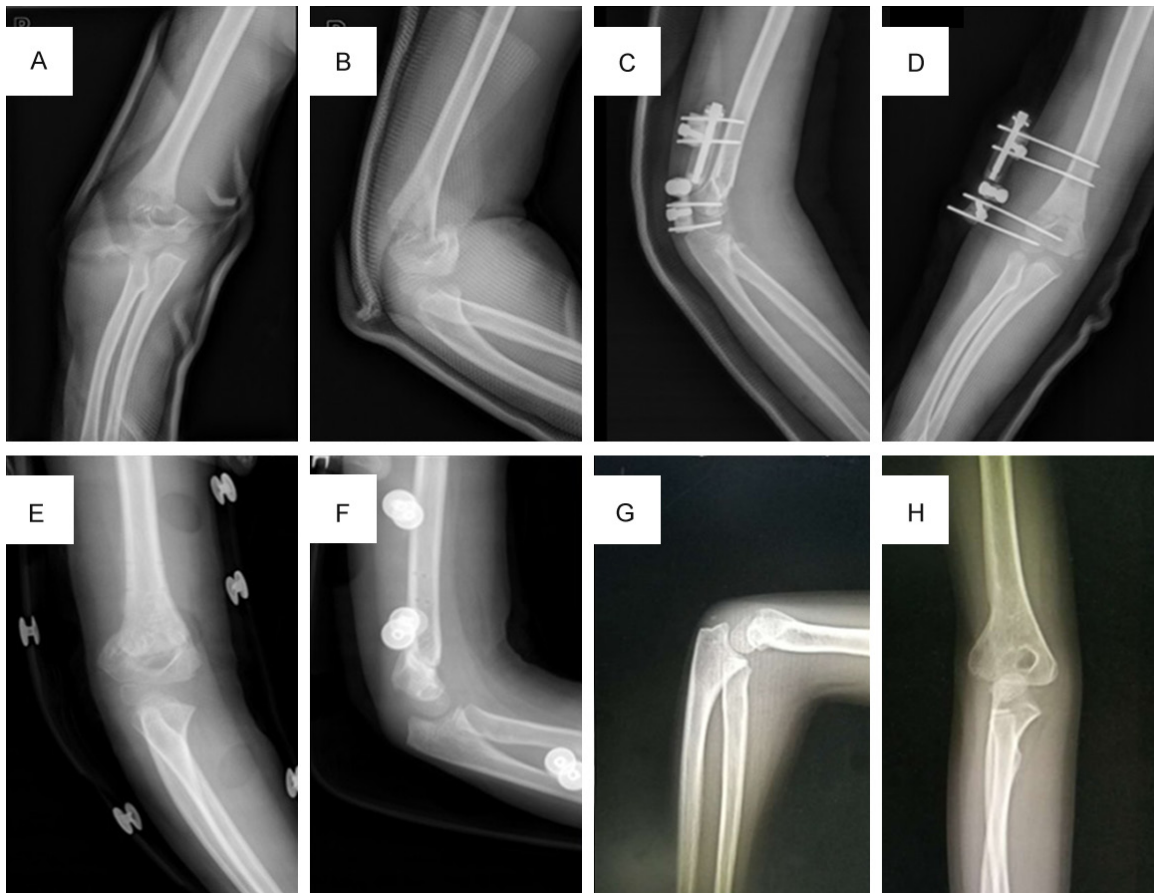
Radiographs showed a displaced supracondylar humerus fracture in elbow (A and B). The fracture was closed reduction and percutaneous fixed by external fixator and four screws after surgery (C and D). After the fracture was union, external fixator was extracted with orthosis (E and F). The follow-up radiographs showed the complete union of fracture without cubitus varus (G and H).
